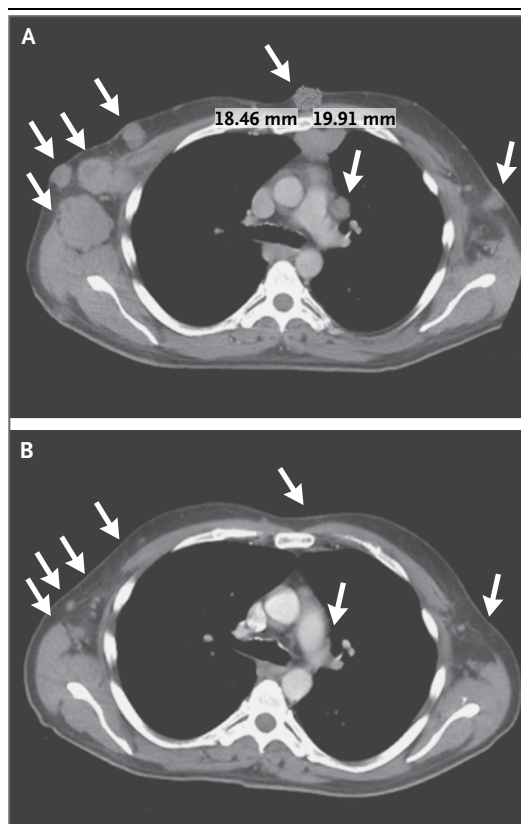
Computed Tomographic (CT) Scans of the Chest Showing Tumor Regression in a Patient Who Received the Concurrent Regimen of Nivolumab and Ipilimumab.
